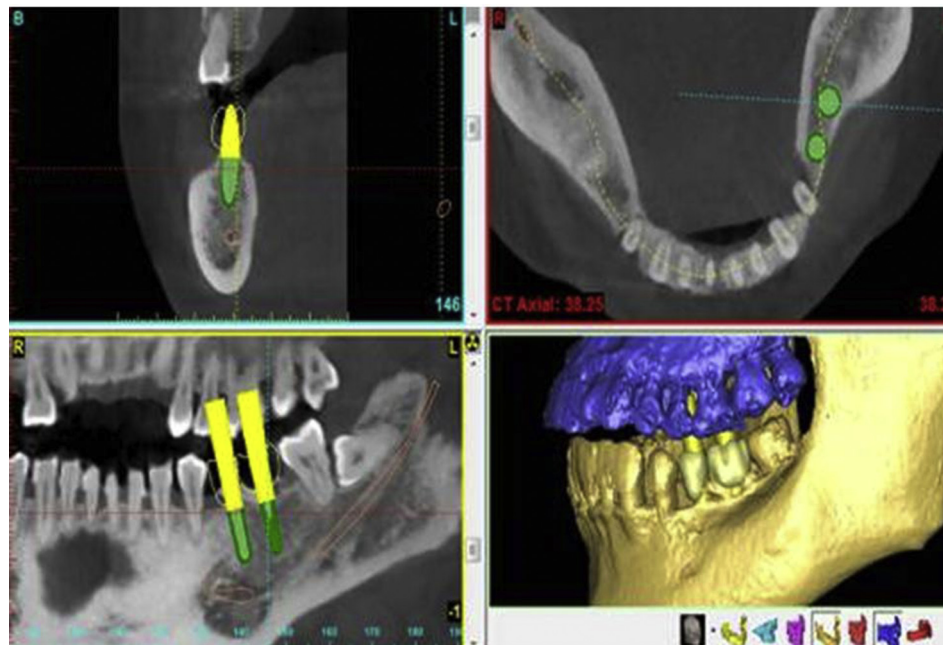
Preoperative planning, including choice of suitable implant sizes and numbers, determination of the insertion depth and direction, and avoidance of vital structures were carried out using Simplant software combined with cone beam computed tomography. The effect of restoration was also predicted by Simplant software.
